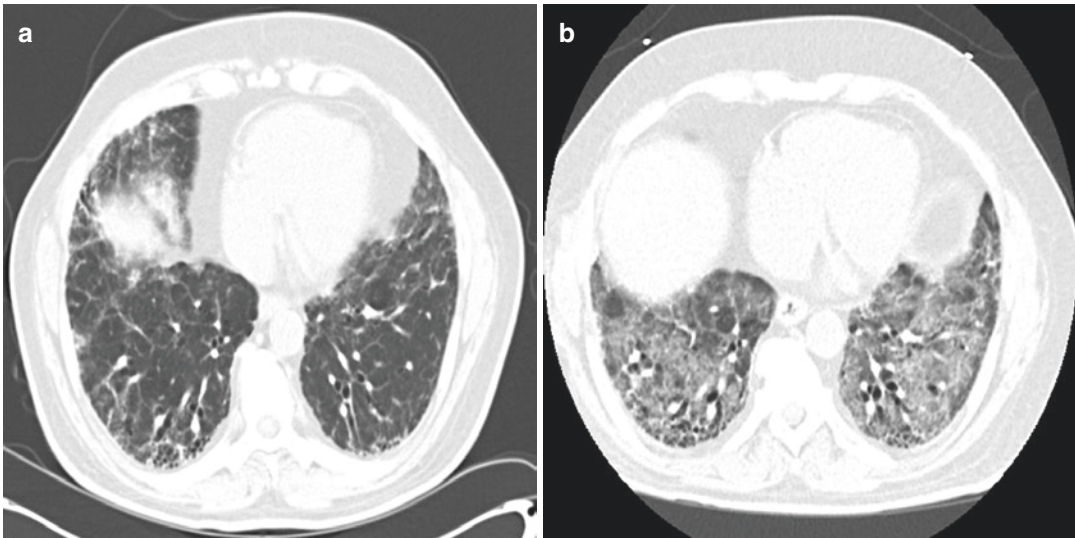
(a) Baseline CT scan of patient with basal predominant interlobular septal thickening and traction bronchiectasis and mild (lower right lung) honeycombing
